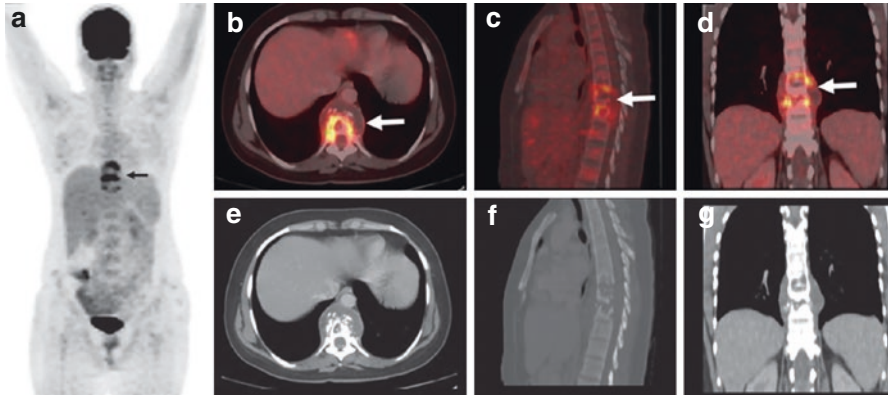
Forty-five years old female presented with pain in the lower back and loss of weight. CT scan of the region showed a lytic lesion with abscess involving D8-D10 vertebrae. A sample from the lesion tested positive for acid-fast bacilli suggestive of TB. The patient underwent 18F-FDG PET/CT to look for the activity and pattern of the disease. Maximum Projection Image (MIP) (a), PET/CT fused (b, c, d), and CT only (e, f, g) images show FDG uptake in a lytic destructive lesion with soft tissue component (abscess) involving D8-D10 vertebrae (white arrow, b, c, and d). FDG uptake higher than the healthier vertebra is suggestive of FDG positive disease (Black arrow, a). No abnormal FDG uptake was seen elsewhere in the visualized organs
